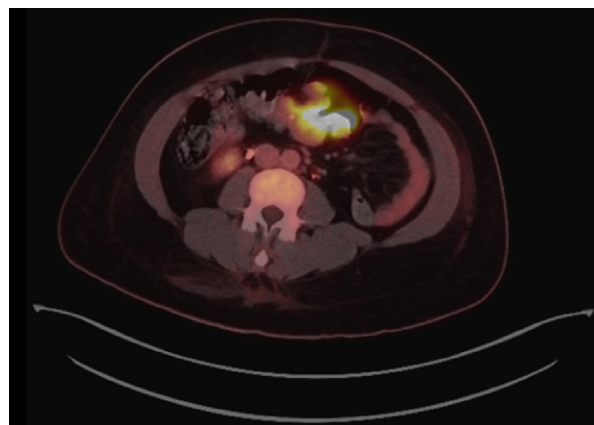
Positron emission tomographic/computed tomographic scan shows a hypermetabolic mass in the mid transverse colon, representing a primary colon malignancy.
